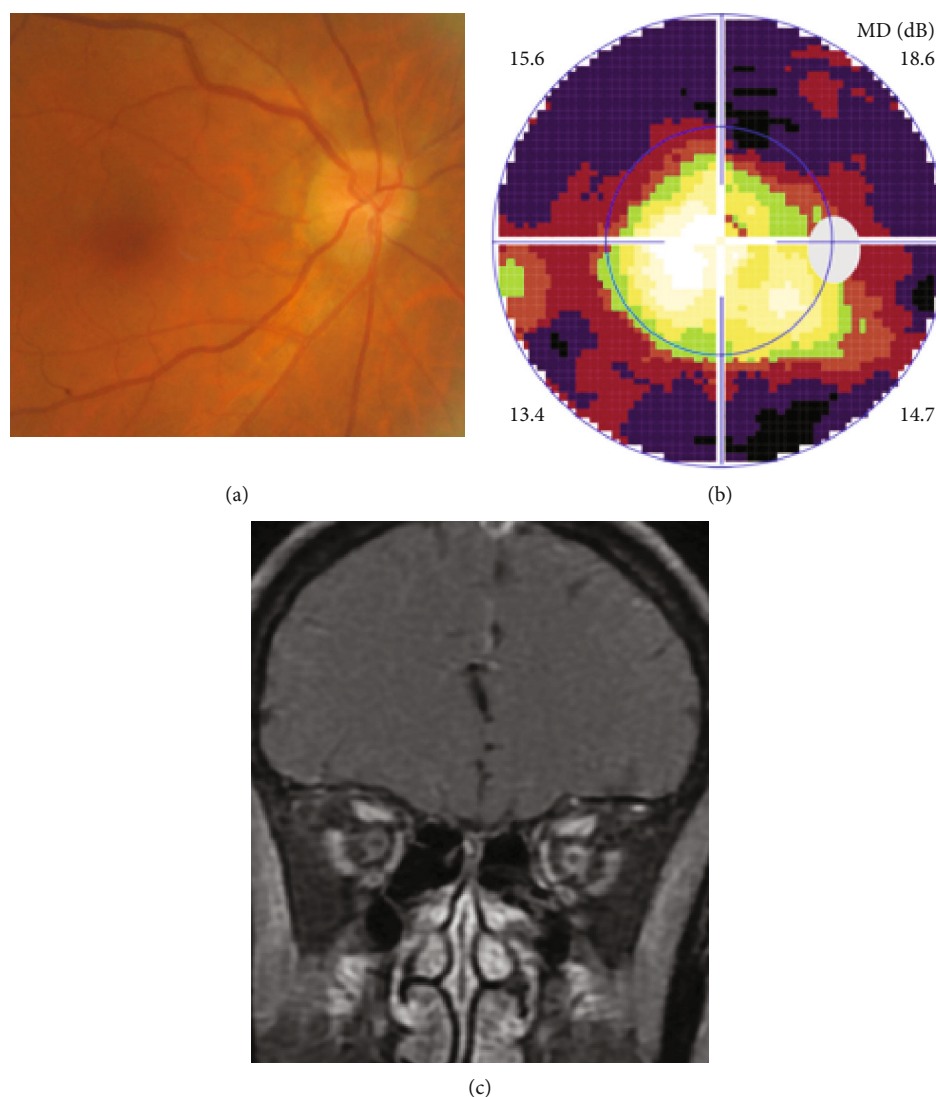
Ophthalmic and MRI examination of definite paraneoplastic optic neuropathy with gastric cancer in Case 4. Fundus photograph showed normal optic disc (a), visual field test showed ring scotoma (b), MRI showed optic nerve enlargement with sheath enhancement in both eyes, more evident in the left eye (c).
